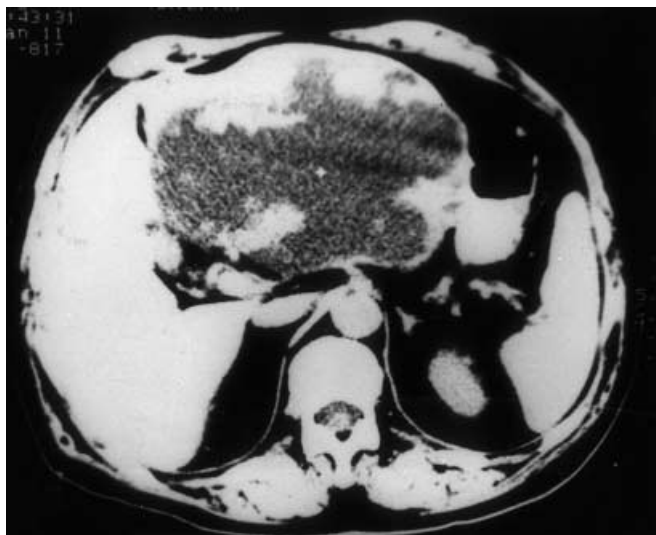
Computed tomography (CT) scan of the abdomen showing a large tumour replacing the left hepatic lobe and extending to the hilum
